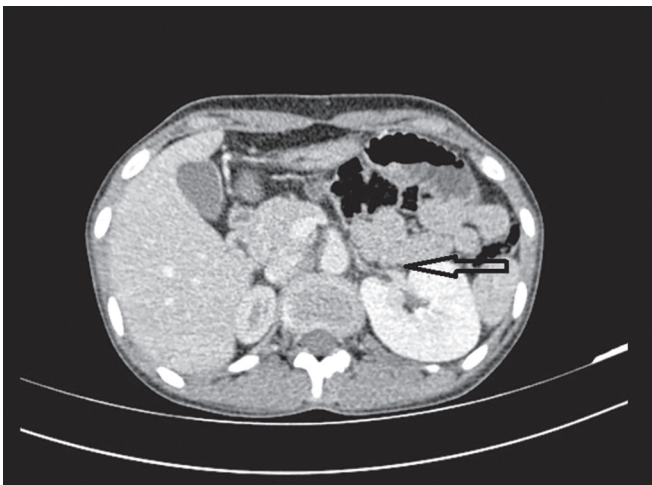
Contrast CT of abdomen shows normal left kidney and left renal artery
